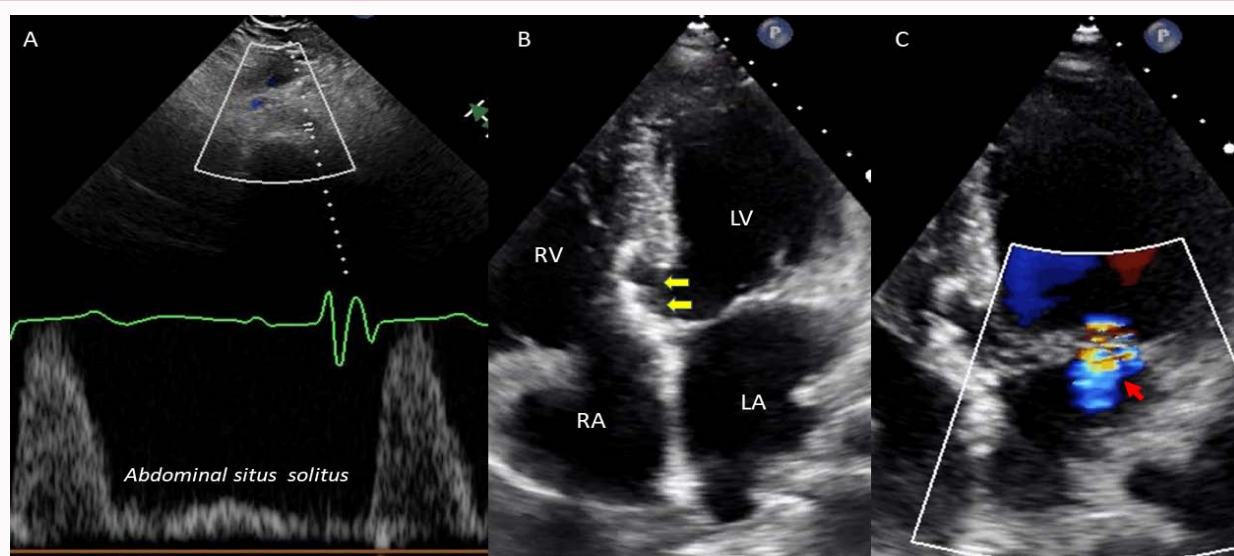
Transthoracic echocardiography after total correction of defect. A- abdominal situs solitus. B- Apical view of the 4 chambers with total correction of the atrioventricular septation defect (yellow arrows). C- Doppler apical view of the 4 chambers that shows mild mitral regurgitation (red arrow). RA: Right Atrium, RV: Right Ventricle, LA: Left Atrium, LV: Left Ventricle
